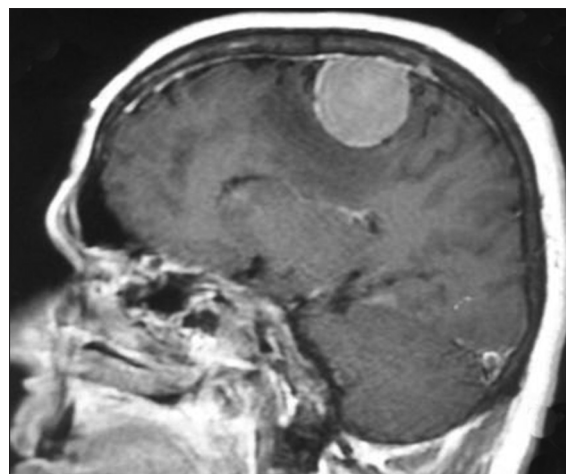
Magnetic resonance imaging showed well defined homogeneously enhancing extra-axial space occupying lesion involving right parietal parasagittal region adjacent to superior sagittal sinus with possibility of meningioma
